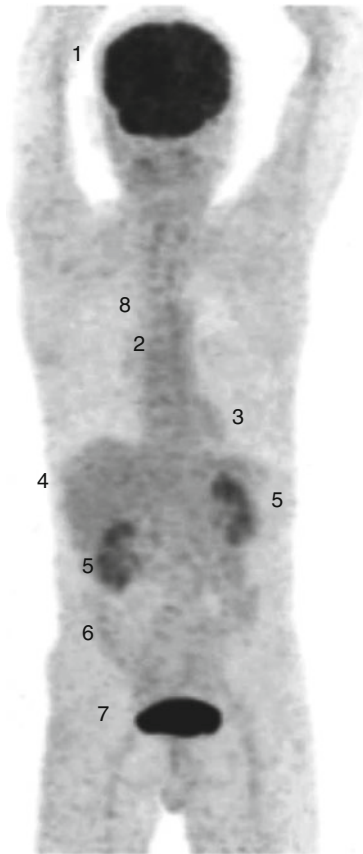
Whole-body FDG PET (maximum intensity projection image) of a patient showing normal biodistribution following injection of 370 MBq of FDG and scanned at 60 min. There is intense FDG accumulation in the cerebral cortex (1) and mild FDG uptake in the bone marrow (2), myocardium (3), liver (4) and in large bowel (6). Tracer excretion is seen in the kidneys (5) and intensely in the bladder (7). There is minimal FDG activity in the lungs (8)
